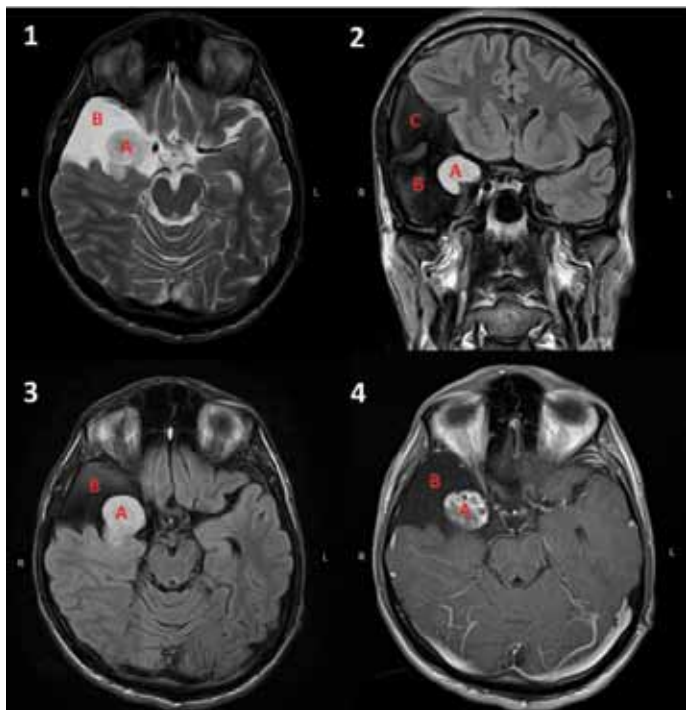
High Tesla MRI of the brain dated 27.04.2016. It was revealed a few pathological pro-cesses: cyst of right temporal lobe (A) and Sylvian fissure of right hemisphere (C), low-grade in-tracerebral tumor (B). 1 – T2 axial; 2,3 – FLAIR coronal; 3 – FLAIR axial; 4 – T1c
